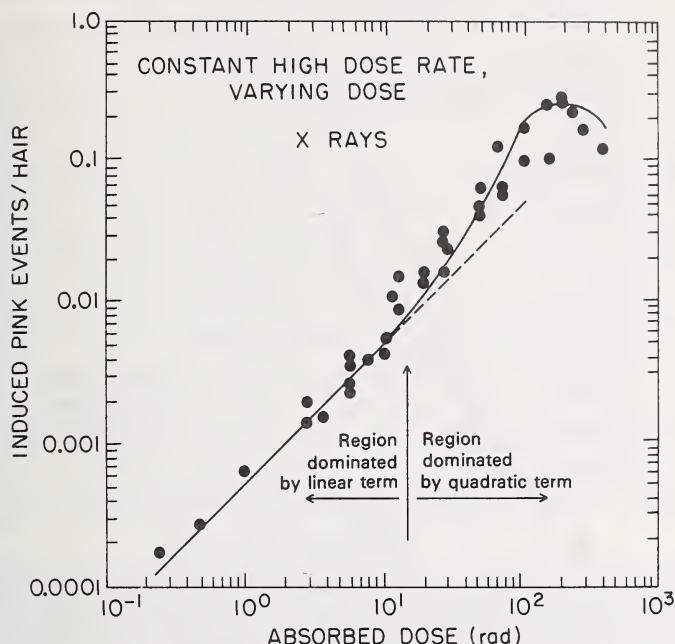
X-ray dose-response curve for induced pink mutations in *Tradescantia*, on a log log plot to show detail in the low-dose range. The solid circles indicate experimental points at high-dose rate. Note that the low dose portion of the solid curve and its dashed-line extrapolation have a slope of unity corresponding to a linear, no threshold dose-effect relationship. The increased slope at higher doses indicates that the response involves a higher exponent of dose. See text for explanation of the linear “ $\alpha_1 D$ ” and quadratic “ $\alpha_1 D + \beta D^2$ ” portions of the curve (data of Sparrow *et al.*, 1972; Nauman *et al.*, 1975; Underbrink *et al.*, 1976).
